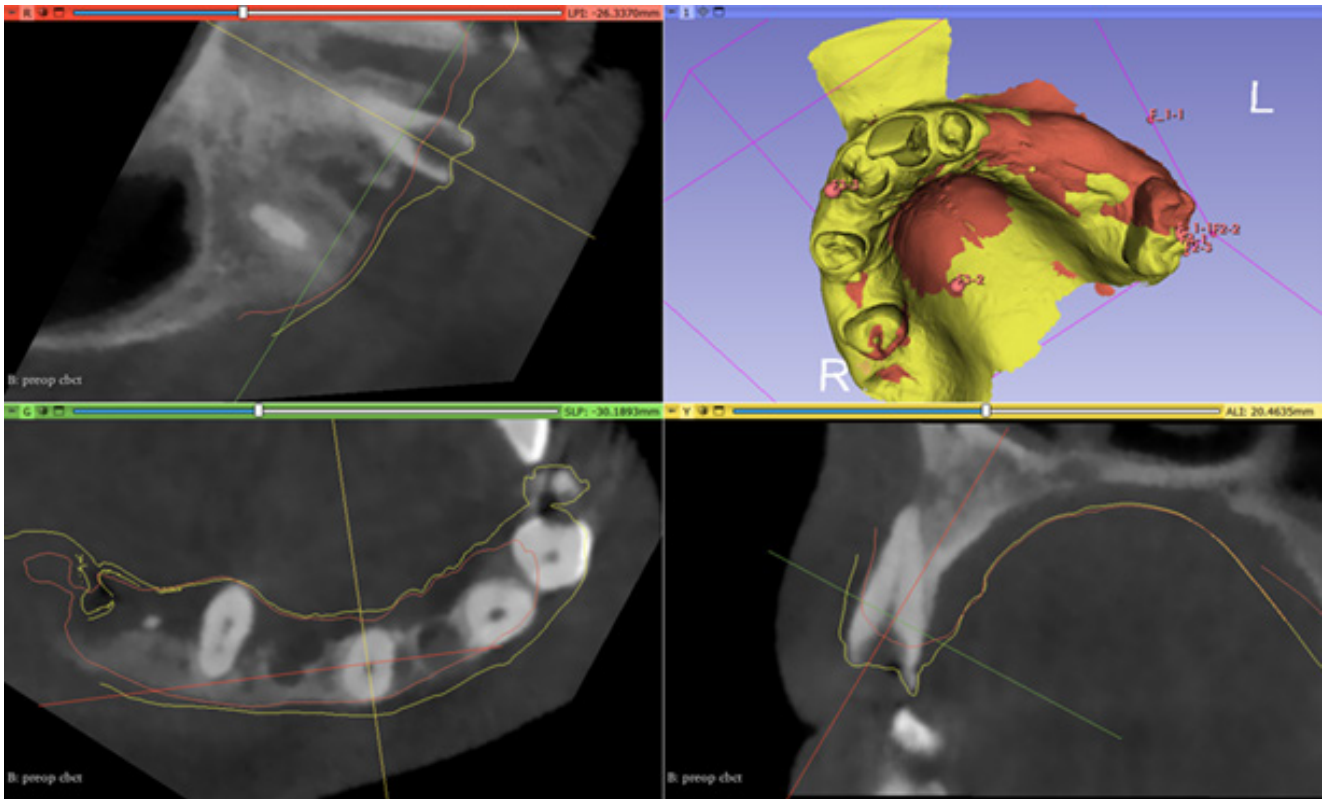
Image showing the 3d superimposition and alignment of the two DICOMS on the preoperative Cone beam CT scan . The white line represents the preoperative soft tissue limits while the red line represents the postoperative soft tissue limits.
